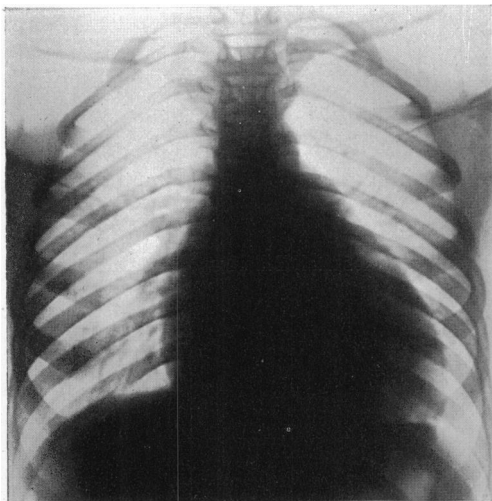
X-ray of chest one day after admission to hospital.
